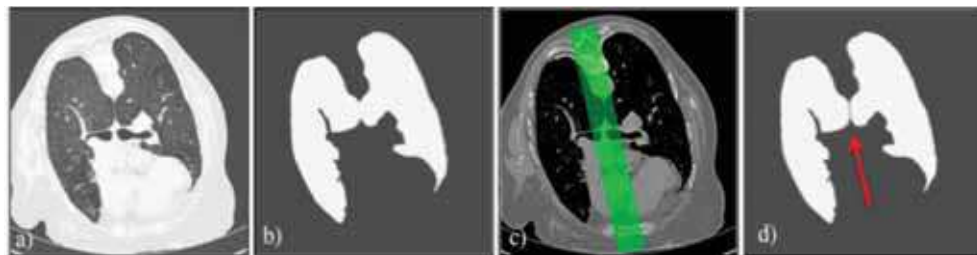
An image of two lungs that are close to each other: appearance on HRCT (a), and the merged region resulted from the thresholding and morphology during the segmentation (b). The potential lung touching area, the 60-pixel-width bar between the spinal cord and the sternum (c), and the two lungs separated, indicated by the arrow, using the detected pleural line (d).
